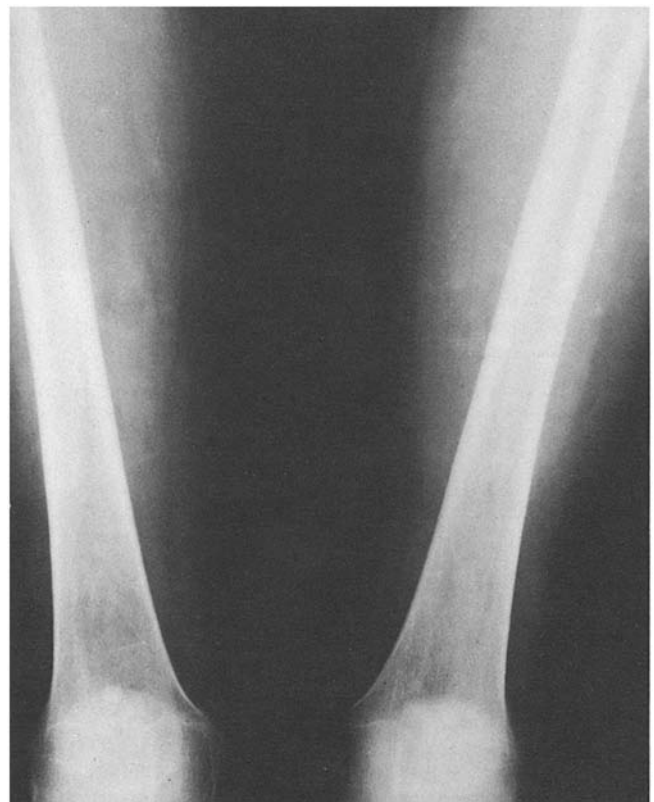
X-ray of femora and knee joints of case 4, two years after starting chemotherapy. Bone lesions have never recurred
